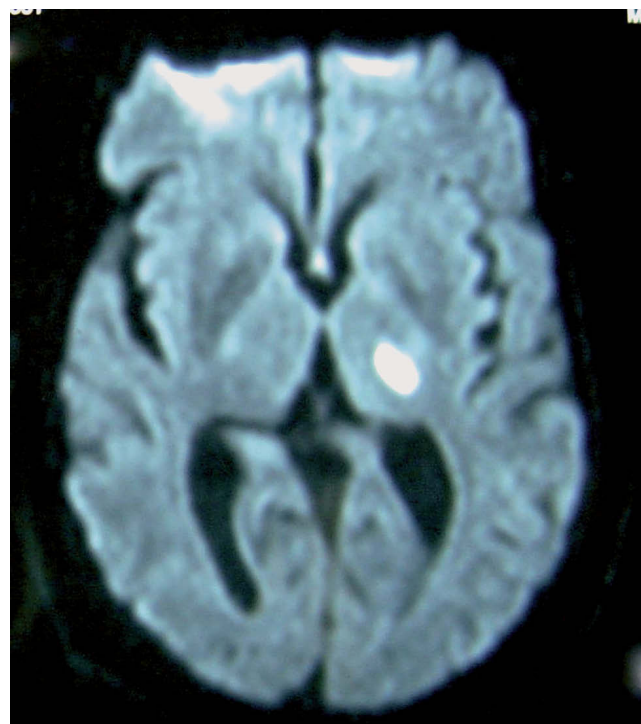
Diffusion sequence of magnetic resonance imaging with hyperintense lesion in the left capsulothalamic region.
